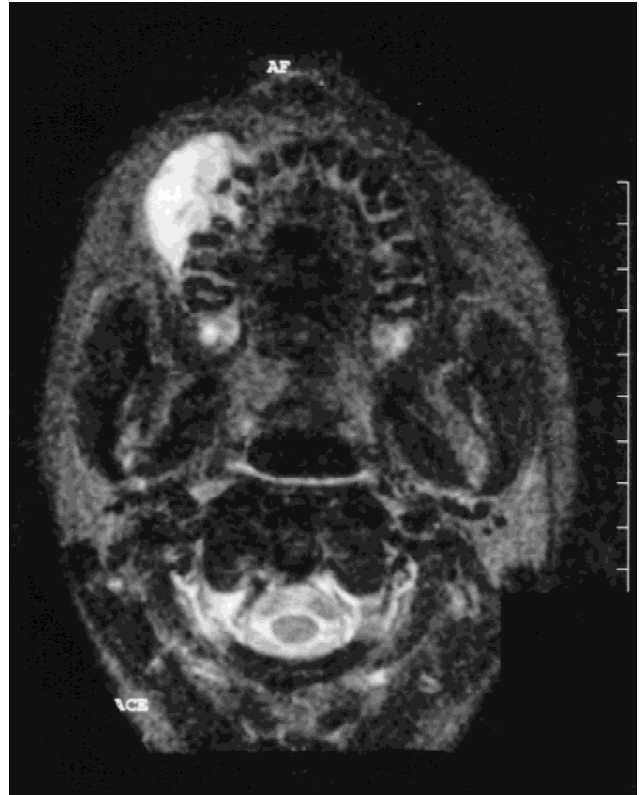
MRI of the maxilla of Case 3, showing a tumor mass of 3×1.3 cm against the external cortex of the right superior maxilla with small lesions in the cortical area.
